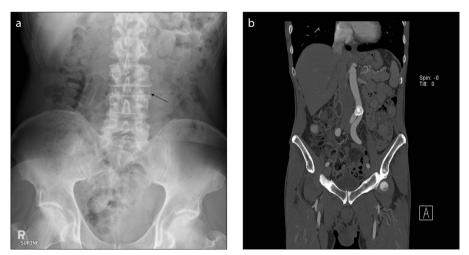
a*, *b*. AXR (a) shows an atrial septal defect (ASD) amplatzer occluder device (*arrow*) that embolized distally into the abdominal aorta just above the level of the aortic bifurcation. CT angiogram (b) confirmed the embolized Amplatzer occluder device in the distal abdominal aorta just above the level of its bifurcation.
